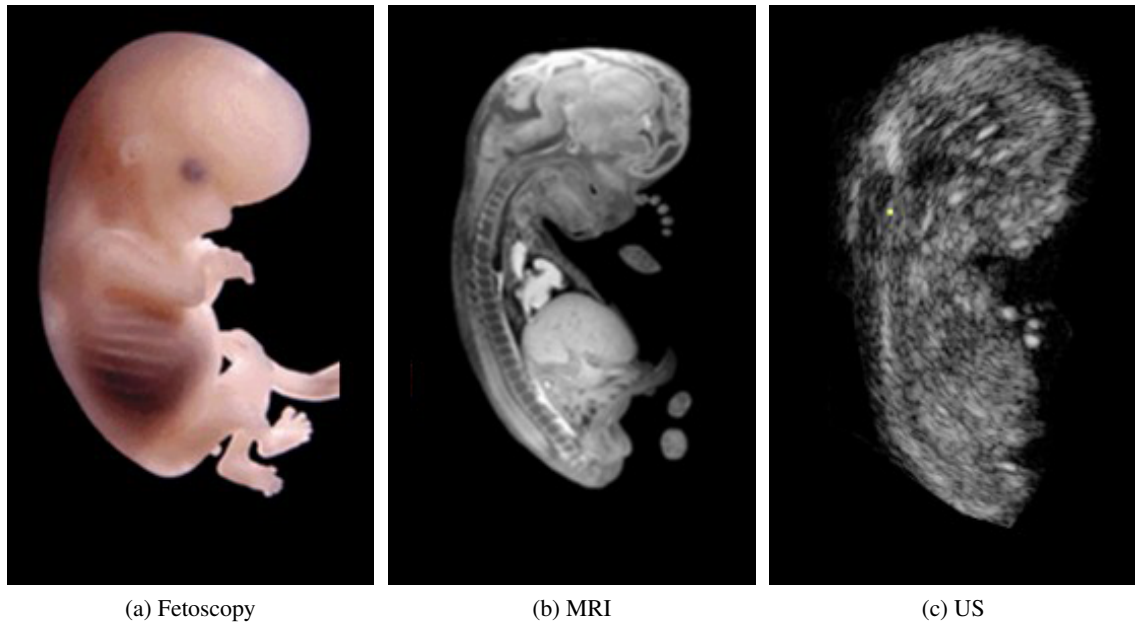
A side by side view of the results of three medical imaging techniques [75]: (a) Fetoscopic image of a fetus. (b) Visualization of a single slice through a fetus obtained by Magnetic Resonance Imaging (MRI). (c) Visualization of a single slice through a fetus obtained by B-mode ultrasound.
